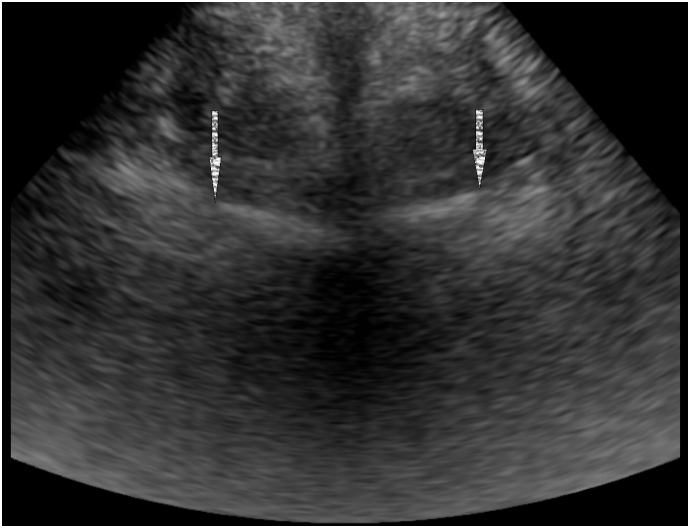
Sonographic imaging of facet joints
